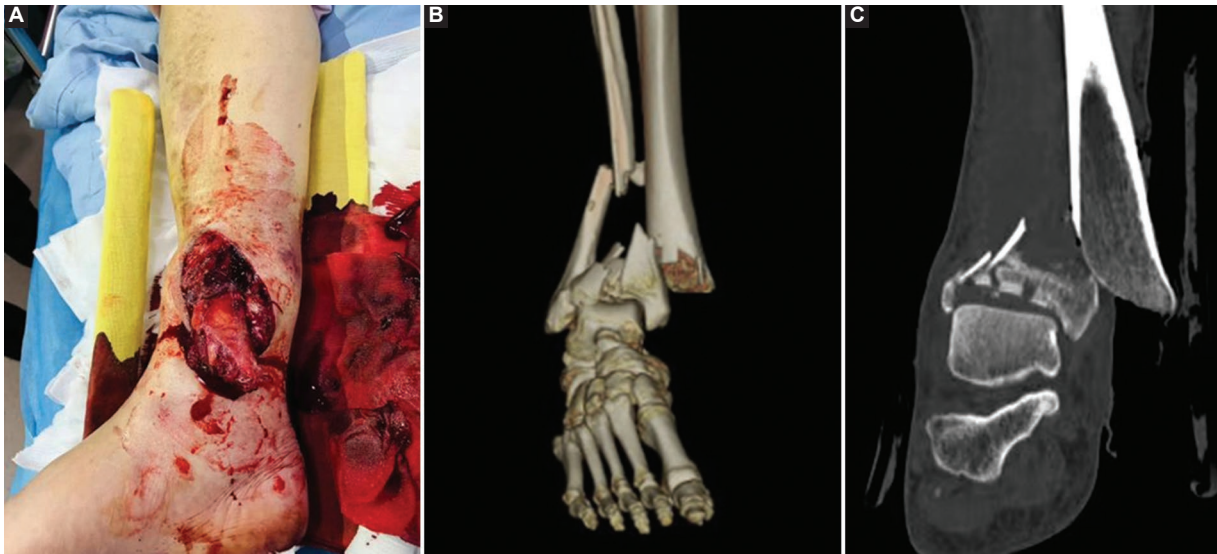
A: examination of the right ankle reveals a soft tissue defect on the medial aspect of the distal tibia. The exposed distal tibia is contaminated. B and C: a post-injury computed tomography scan confirms a comminuted fracture of the distal tibia with bone defects on the articular surface.
